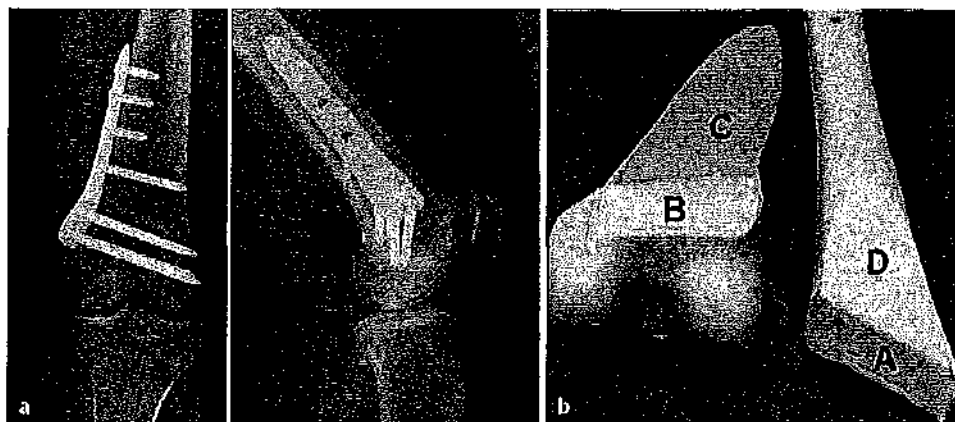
A Follow-up radiographs that show bone healing and bone surfaces after biplane supracondylar osteotomy in a saw bone model. a, Antero-posterior (AP) and lateral views show full consolidation at 6 weeks follow-up. (With permission from [60], page 132, Fig. 4E–F) b, Bone surfaces following a medial closed-wedge biplane osteotomy in a saw bone model: Transverse osteotomy plane surfaces *A* (proximal) and *B* (distal), frontal osteotomy plane surfaces *C* (ventral) and *D* (dorsal). Summation of these surfaces in square centimeter (cm²) stratified by anatomical location show an increase in area compared to a single plane supracondylar osteotomy. (Adapted with permission from [53])
